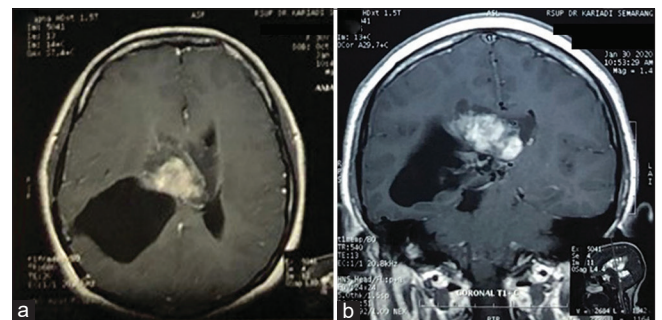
Post-operative cranial magnetic resonance imaging in T1 sequence with contrast (A: Axial; B: Coronal) demonstrated the remaining mass (AP 4.09 × CC 3.01 × LL 4.13 cm) after STR
